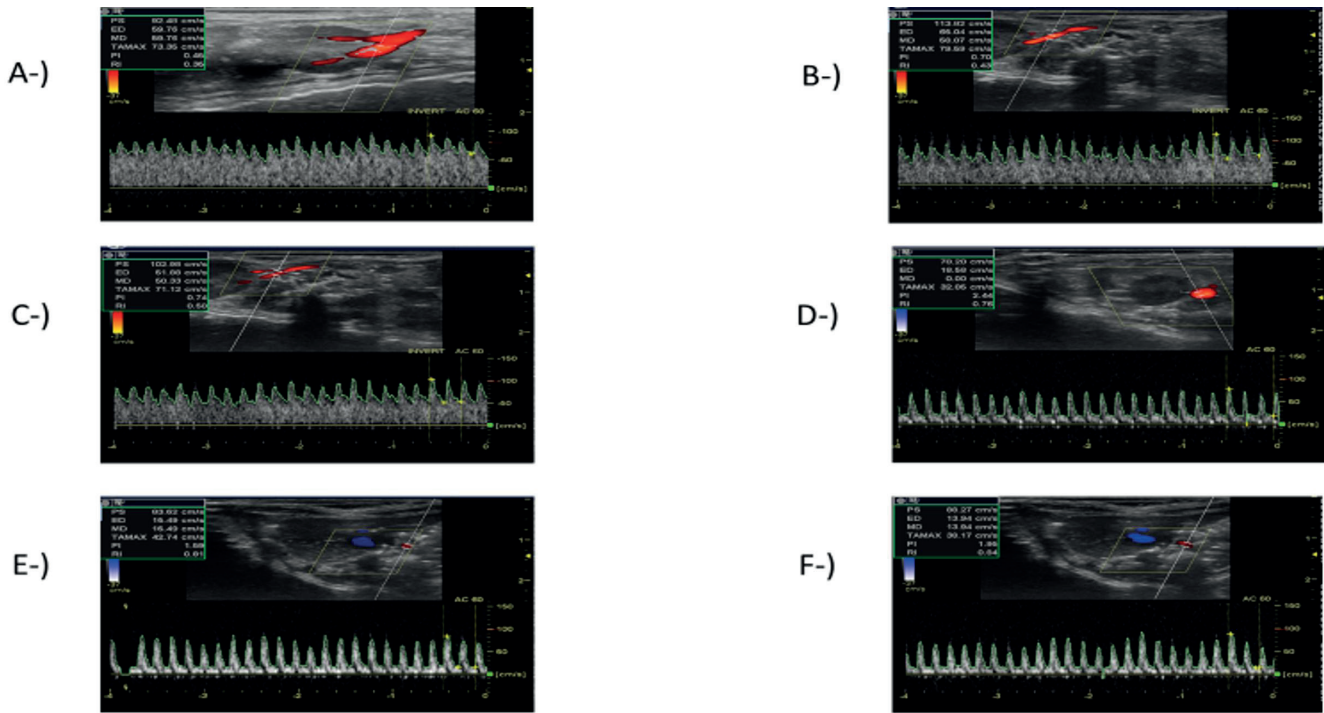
A sample ultrasonographic measurement of RRI in the groups
